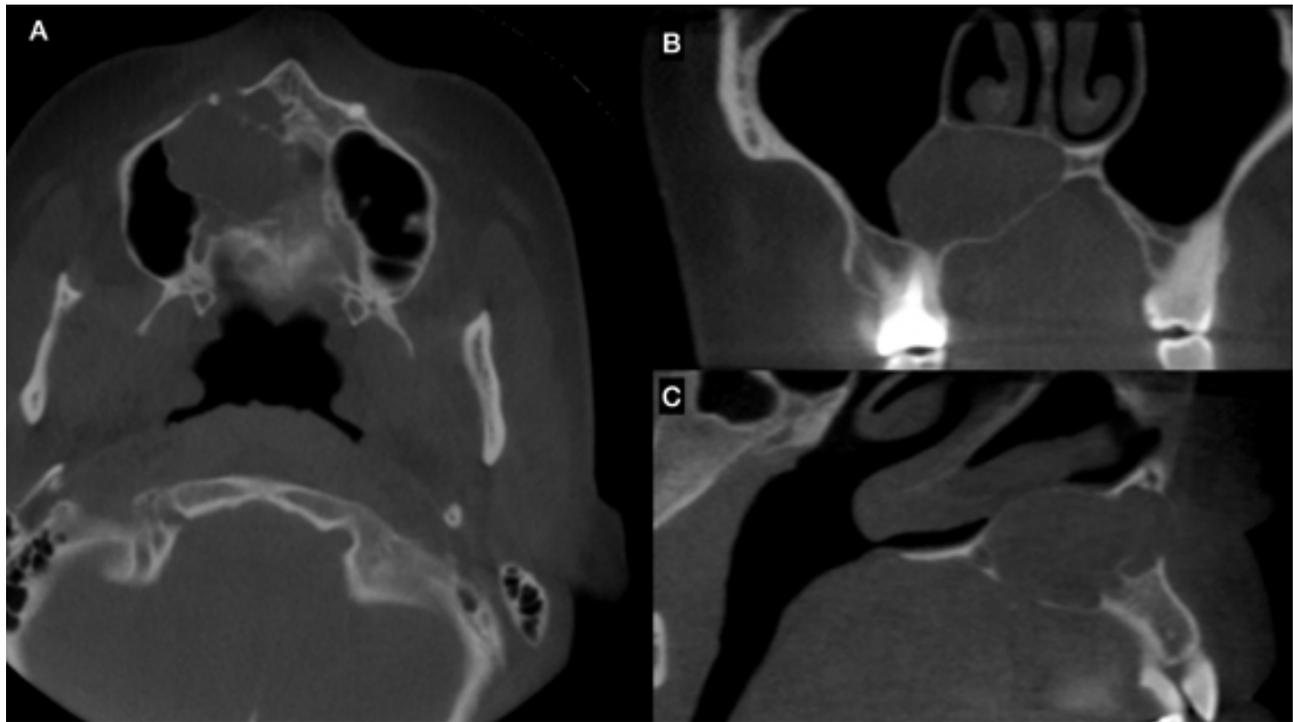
CT showing a well-defined area in the maxillary bone. A) axial section involved the maxillary sinus and nasal floor. B) Coronal section showing the displacement of the right turbinate. C) Sagittal section showing the compromise of the teeth with the tumor.
